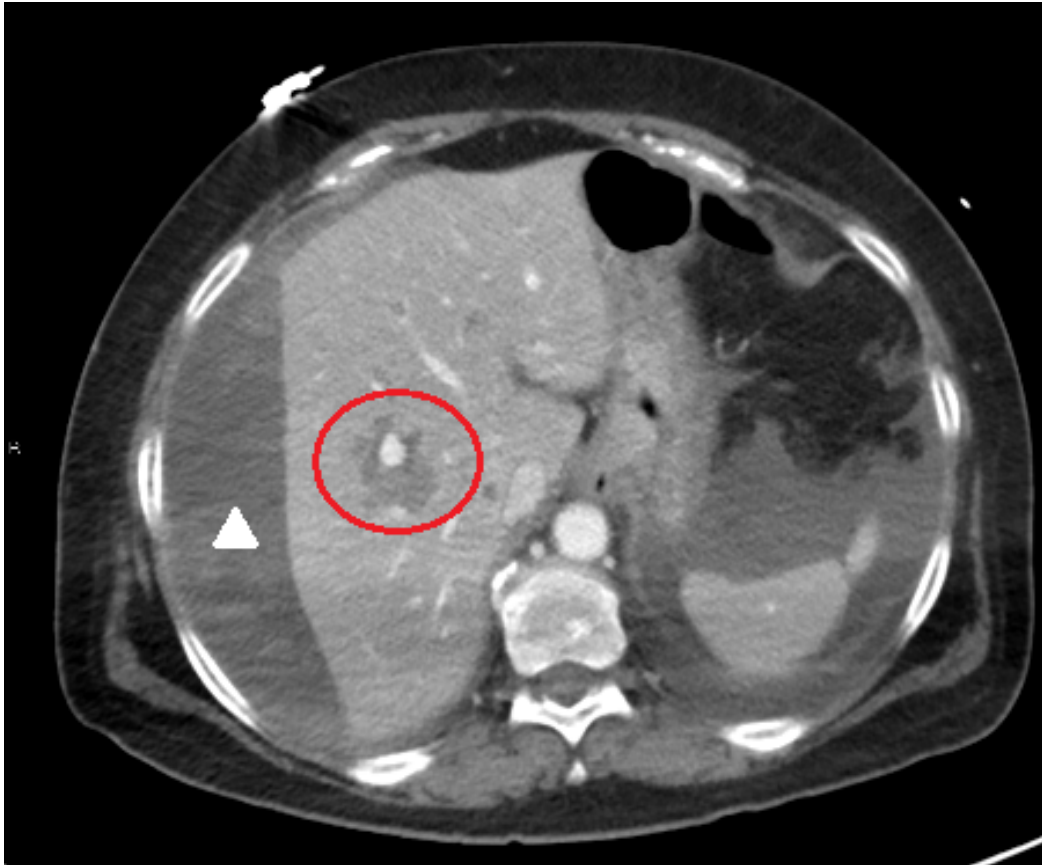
Abdominopelvic CT with intravenous contrast. An encapsulated subcapsular heterogeneous and high density collection in relation to a hepatic subcapsular hematoma (white arrowhead) is observed. In addition, several poorly defined hypocaptant liver areas were identified, one in segment 8 in relation to a phlegmonous area, with a rounded image of 11 mm in relation to a phlegmonous area with a hepatic artery pseudoaneurysm and active bleeding in the thickened area (red circle). There was also a moderate amount of intra-abdominal free fluid with a high density component, compatible with a hemoperitoneum.
